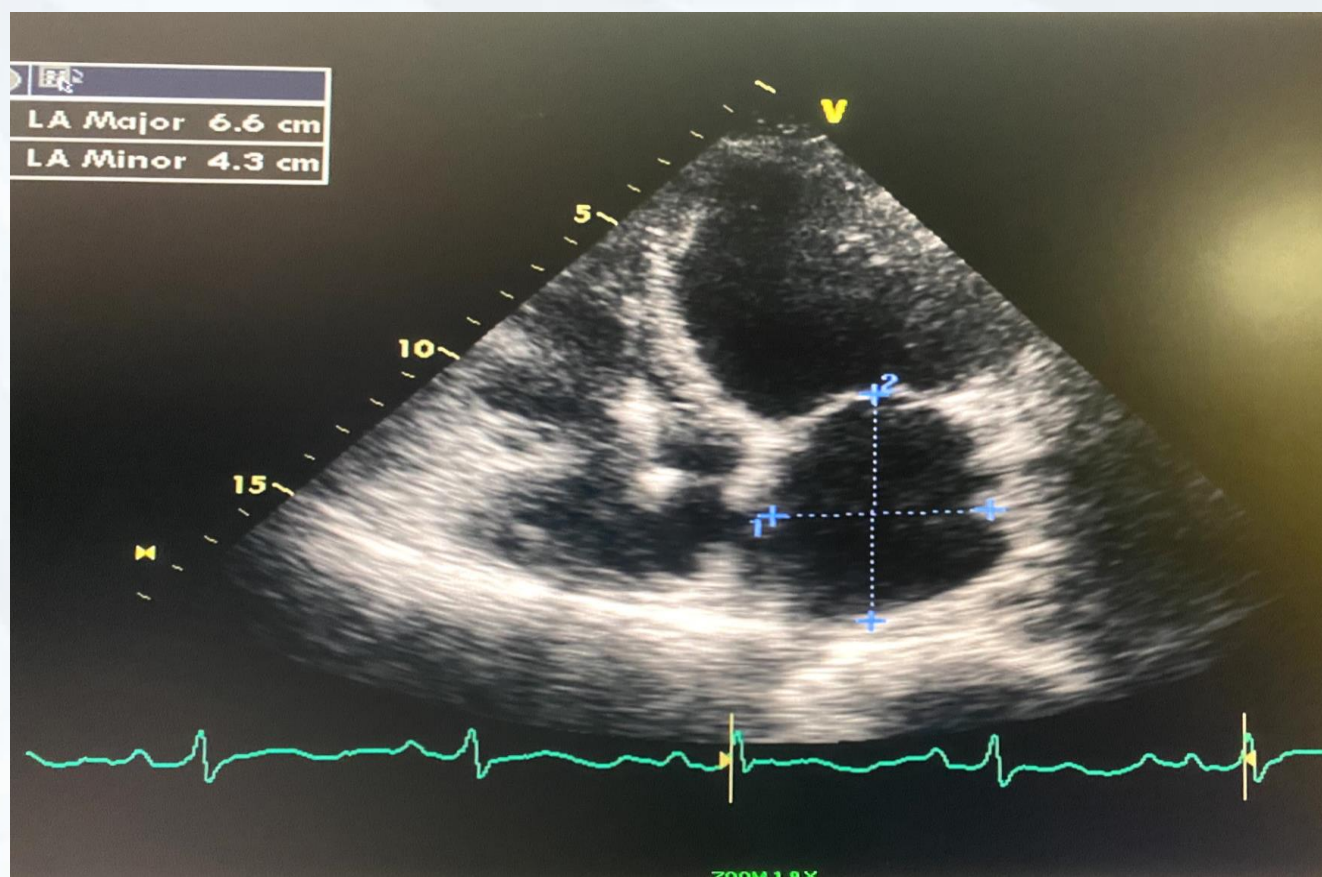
Echocardiogram showing increased left atrial size at 6.6 cm
